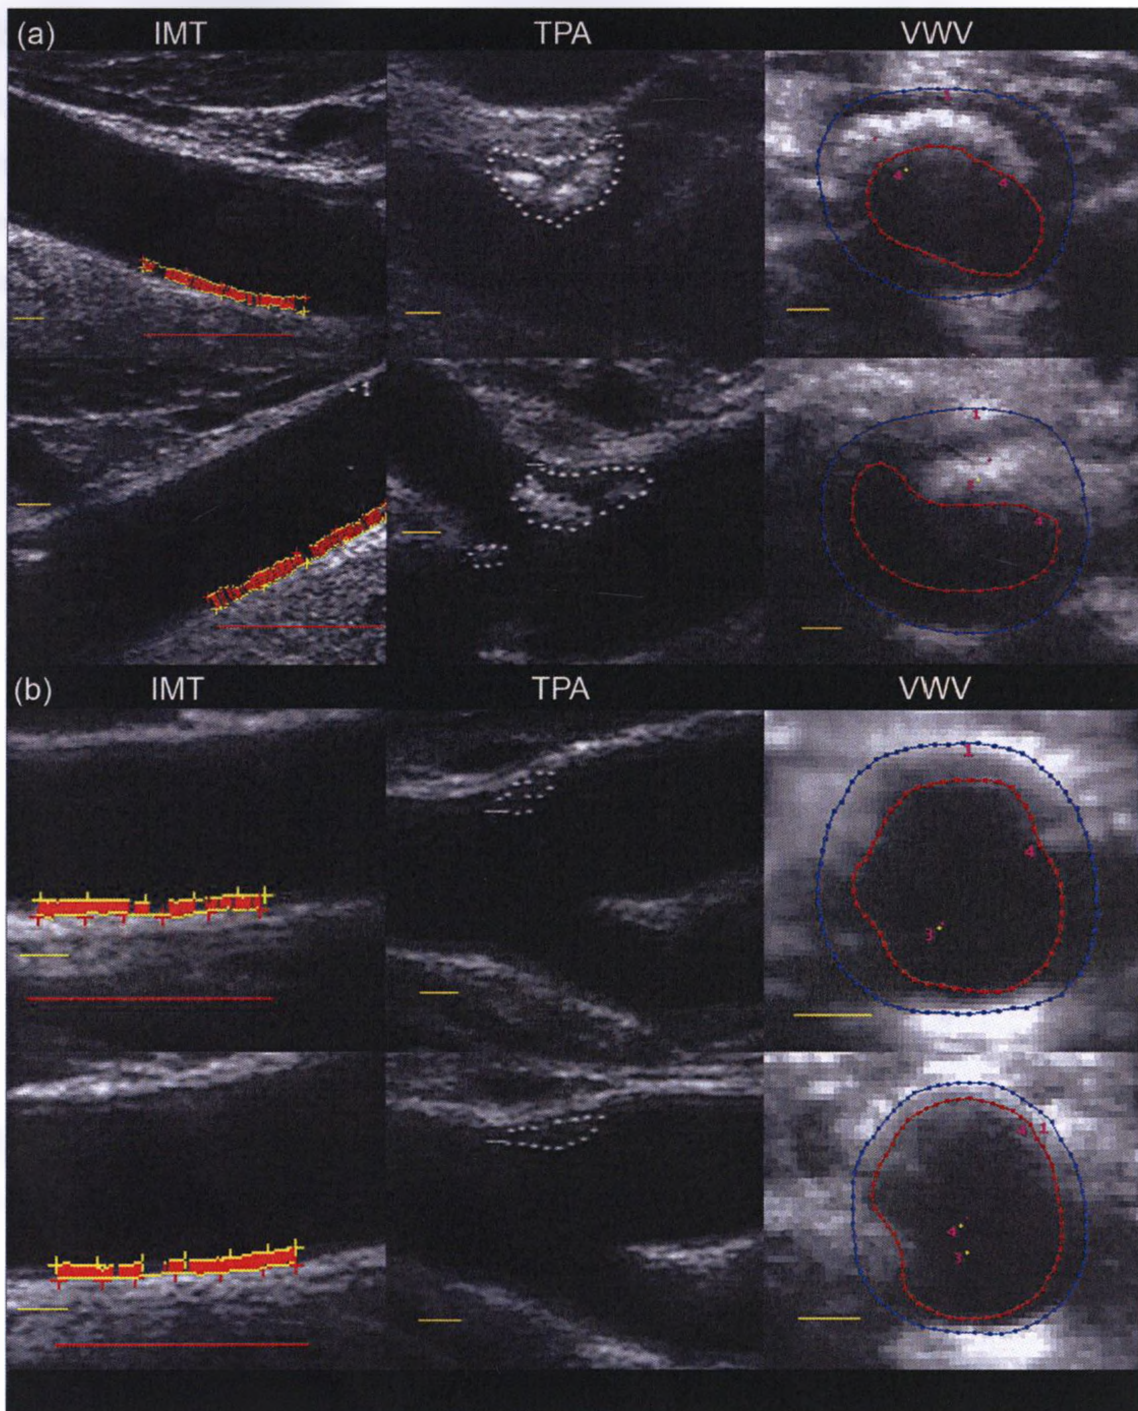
Ultrasound Measurements in Representative Subjects.
